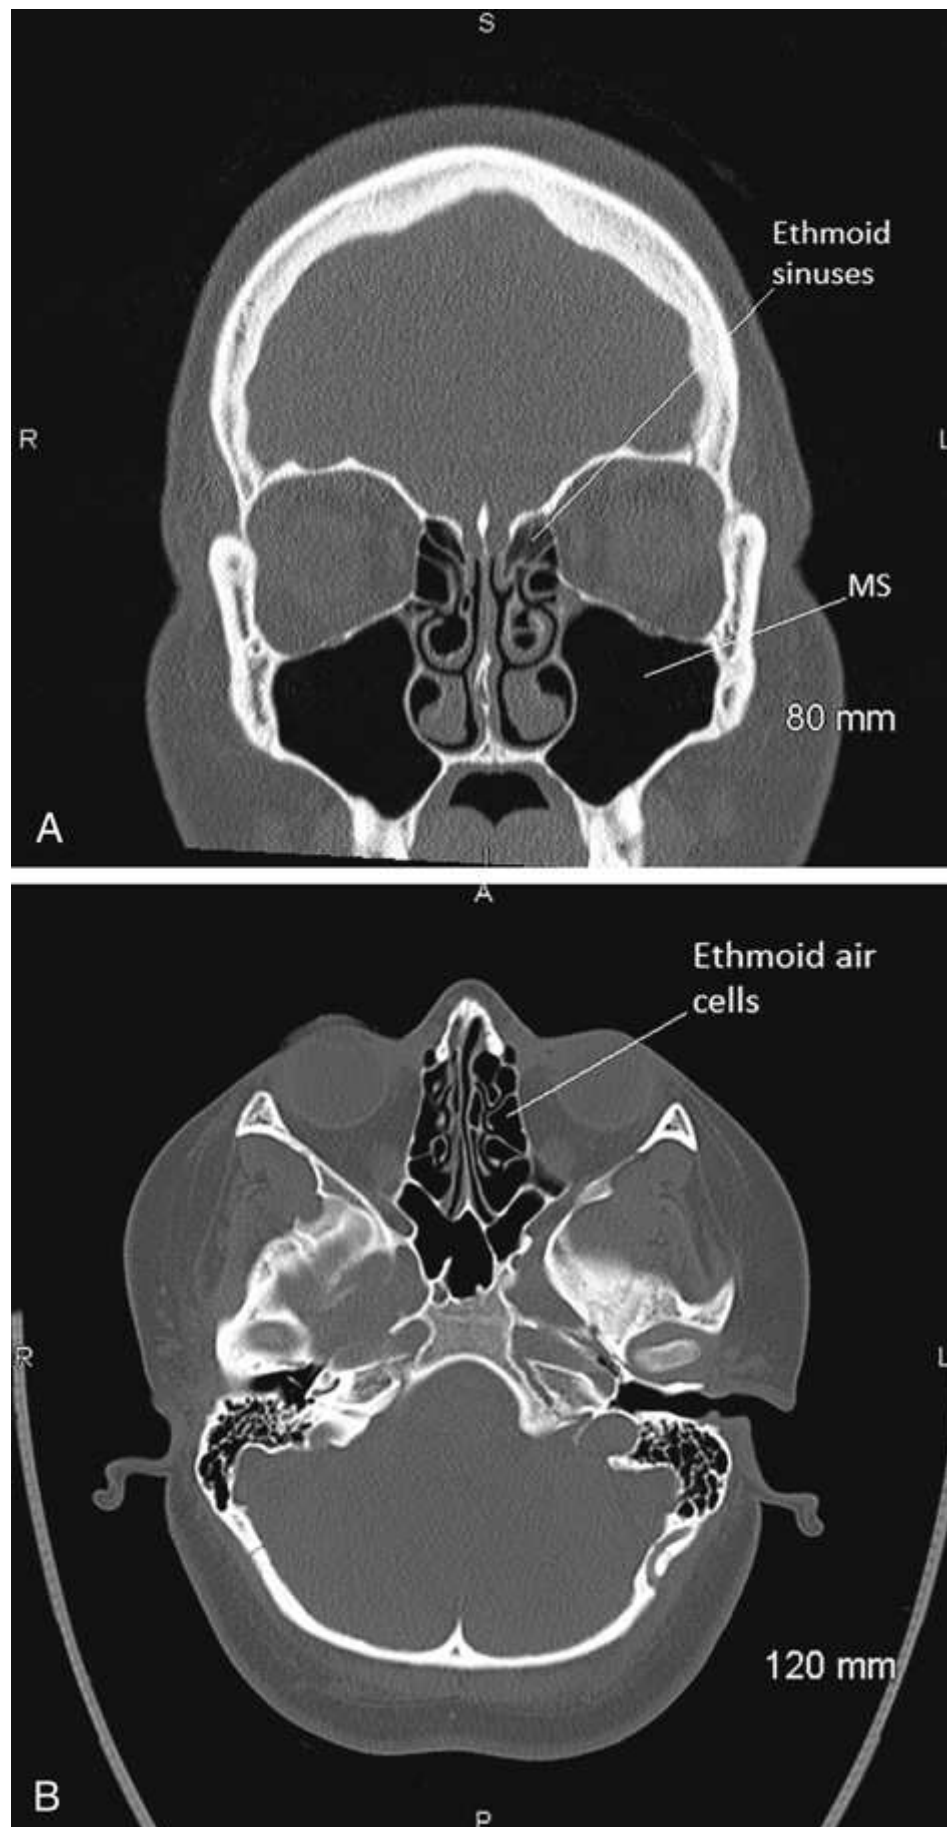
(A) Coronal CT image of ethmoidal sinuses. (B) Axial CT scan of ethmoidal sinus. MS, Maxillary sinuses. Courtesy Bryan Harrison, RT(R) (CT), NEA Baptist Memorial Hospital, Jonesboro, AR.
